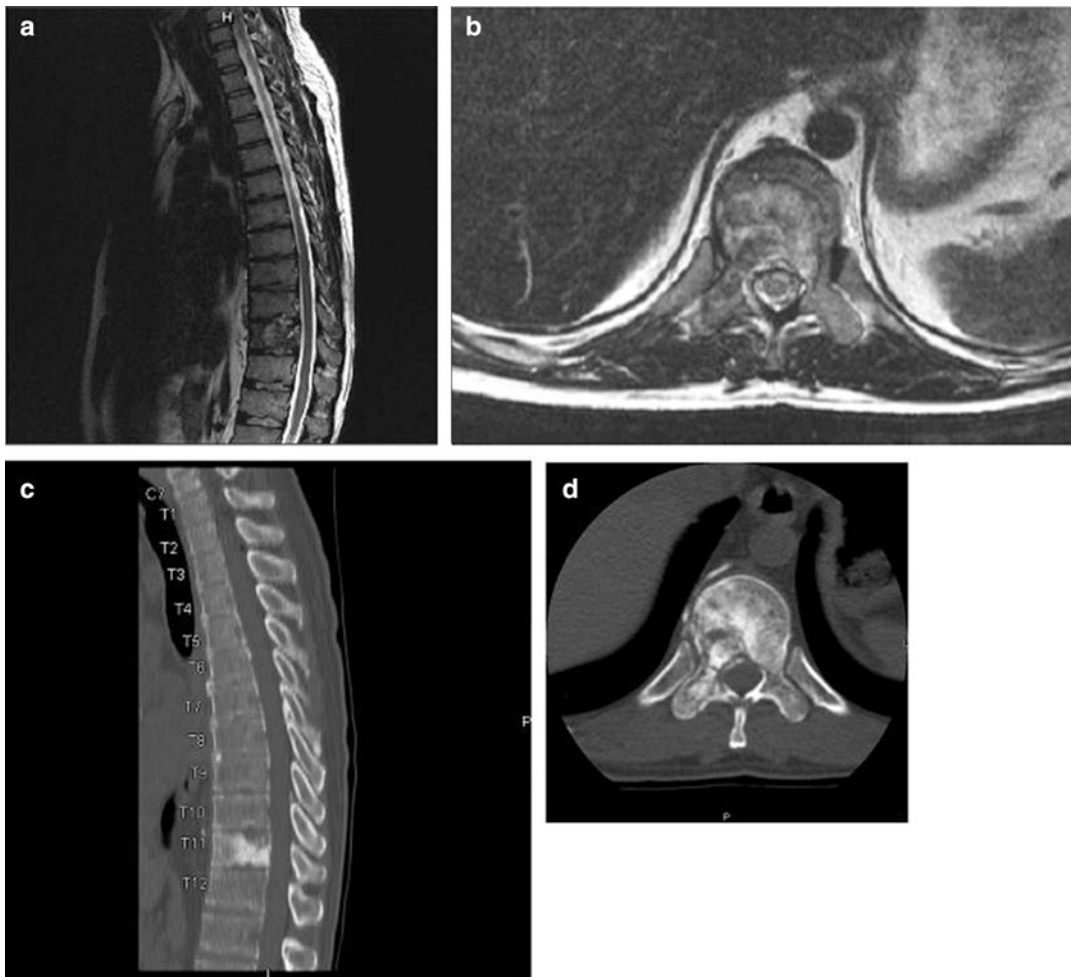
Case 1. (a) Preoperative T2 W MRI and (b) CT demonstrating T10 lesion with marked reactive changes in the vertebral segment indicative of Enneking Stage IIA malignancy. (c) Sagittal CT demonstrating tumor confined to the T10 vertebral body and (d) Axial CT showing
